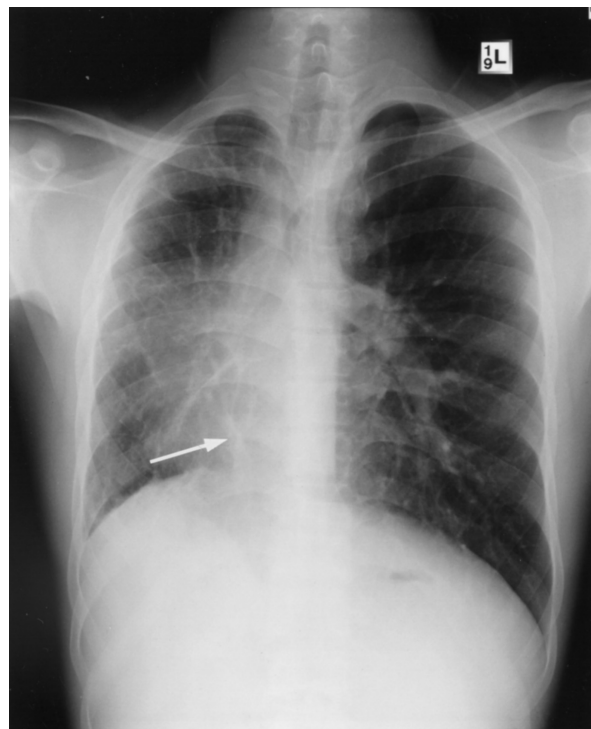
Frontal X-ray film at this admission, showing a volume reduction of the right thorax, dextroposition of the cardiomeastinal structure and a scimitar vein along the right-side heart border (arrow), which indicates an anomalous pulmonary venous return.
